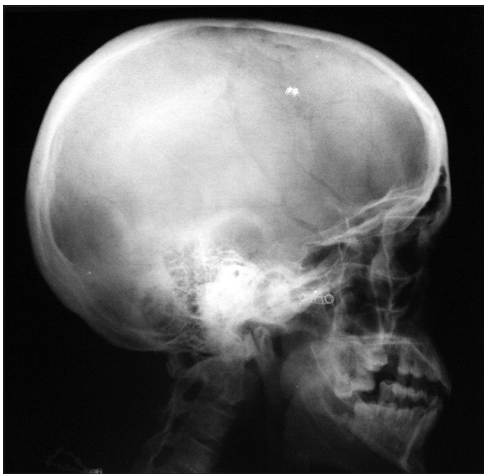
X-ray skull showing spring in the right infra temporal fossa
